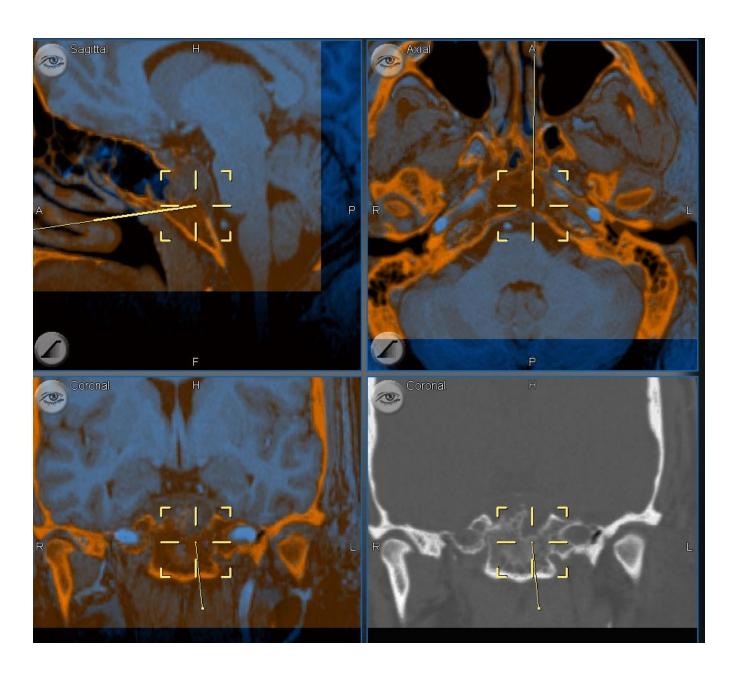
Image Fusion of MRI/CT/MRA
